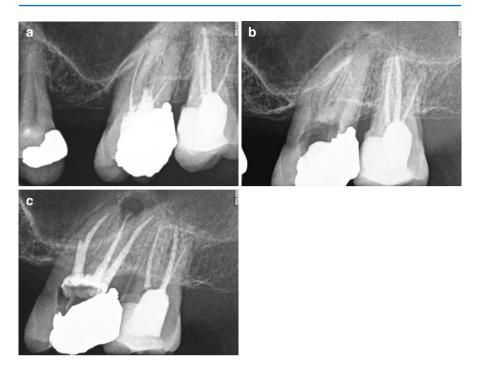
(a) Preoperative radiograph of a retreatment case with two fragments, one in each buccal root of a maxillary left second molar. (b) Removal of the fragments with the file bypass technique. (c) Immediate post-obturation radiograph. Note the ledge formed
